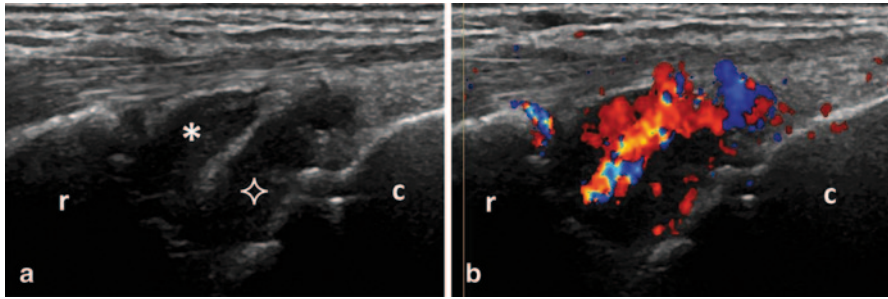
Longitudinal view over the midline dorsal aspect of the wrist showing B-mode synovitis (a) with Doppler signal (b) in radio-carpal (*asterix*) and midcarpal (*star*) joints; *r* radius, *c* capitate
